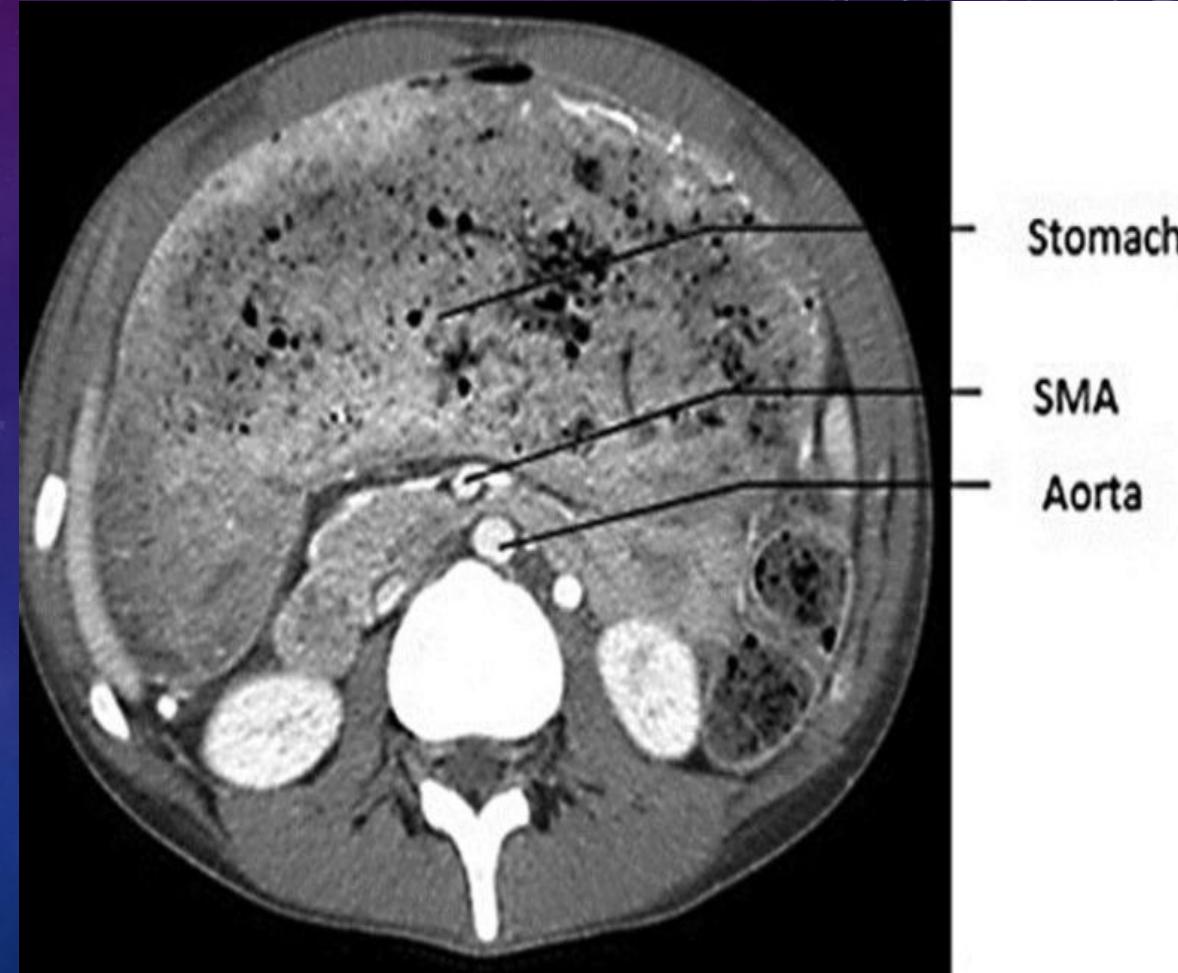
CT nález pacientky – komprimované duodenum
